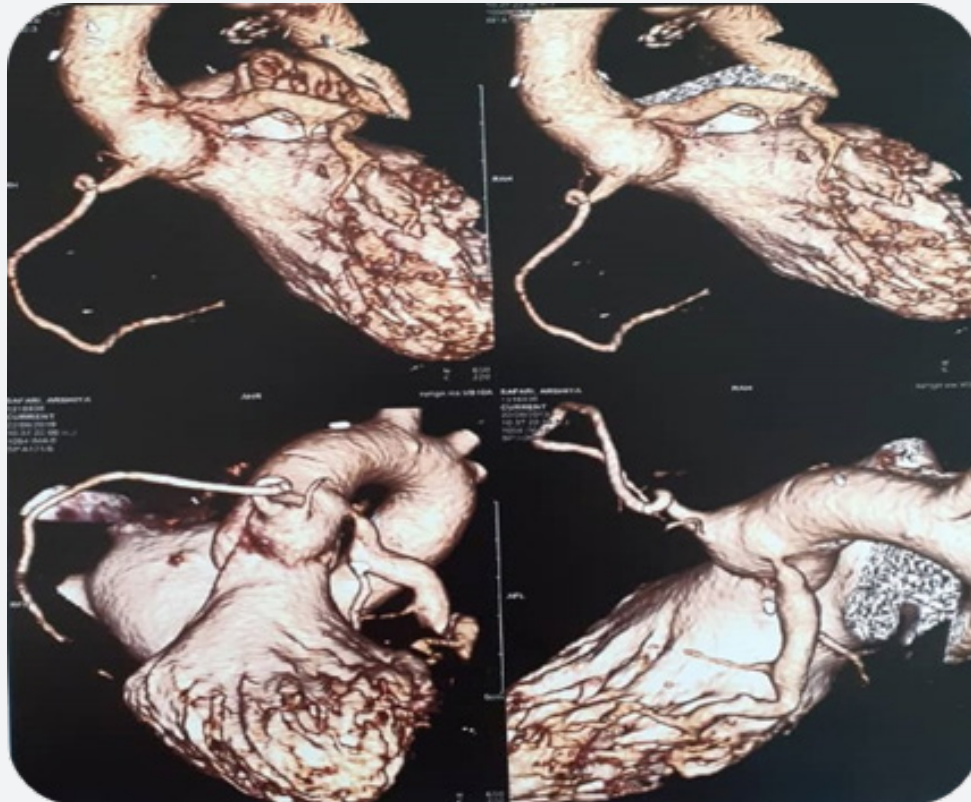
CT scan showing severe stenosis at the origin of the left main coronary artery following surgery.
